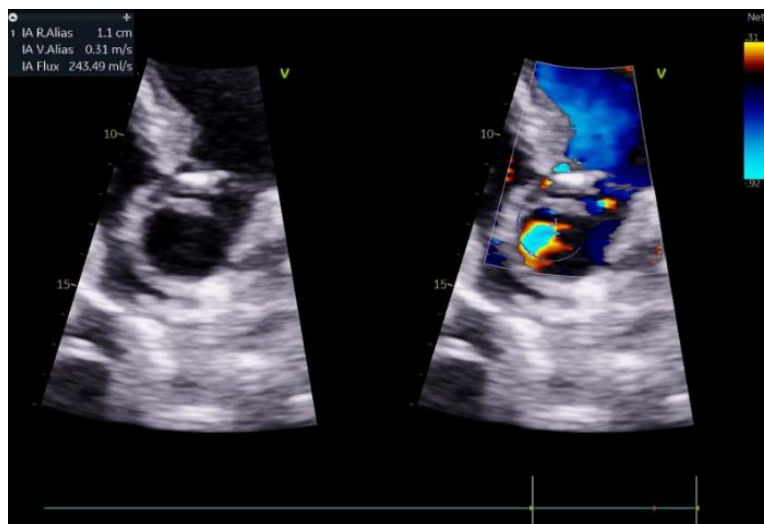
Aortic insufficiency on 3D transthoracic ultrasound
